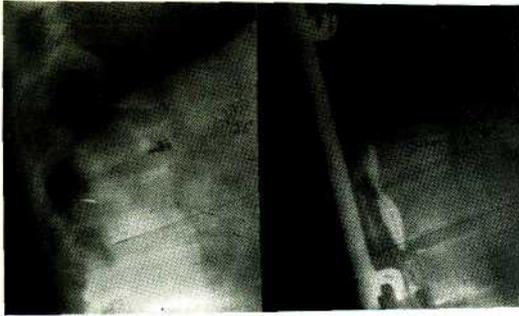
Lateral X-rays of Case II, shows the improvement of kyphos angle pre and postoperatively, respectively.
